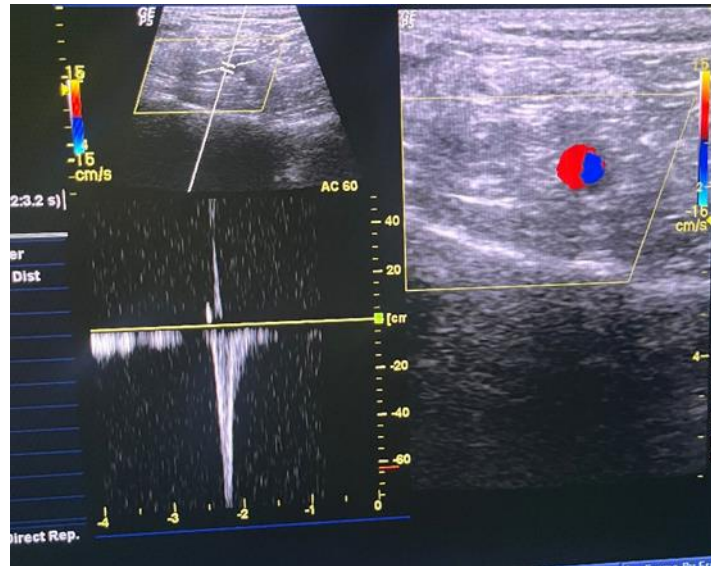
Color Doppler Flow Imaging – Right side – Popliteal vein showing normal doppler spectrum and response to distal augmentation. Left side – Compressed popliteal vein and patent popliteal artery
